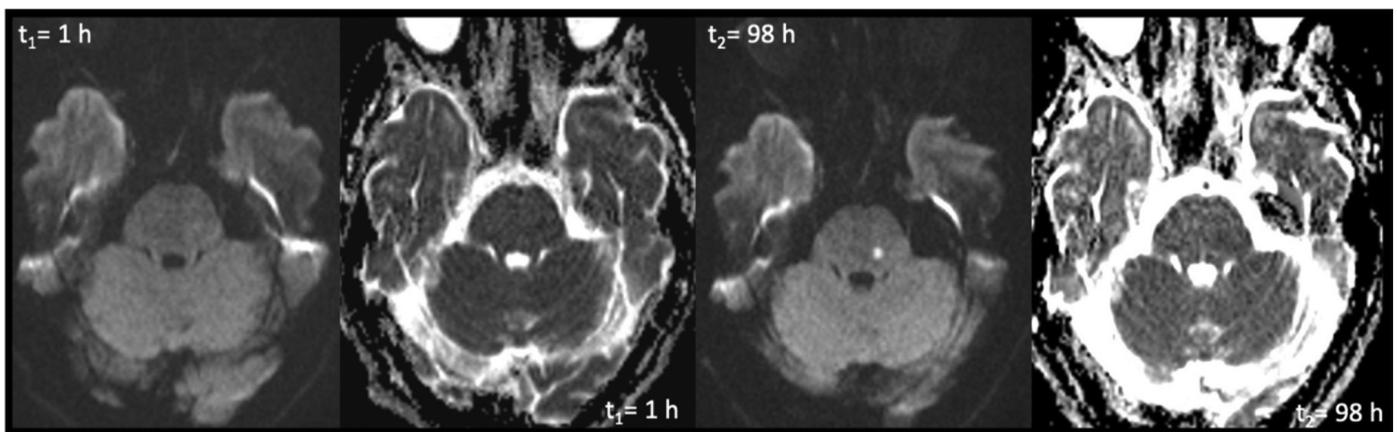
Vertigo: A 73-year-old woman with hypertension was admitted with acute onset vertigo and mild ataxia. (admission NIHSS: 4; 24th-hour NIHSS: 4). The left mid pons small infarction, which cannot be visible in DWI obtained at the end of the first hour of the symptom occurrence, is clearly observable at the ninety-eighth hour DWI
